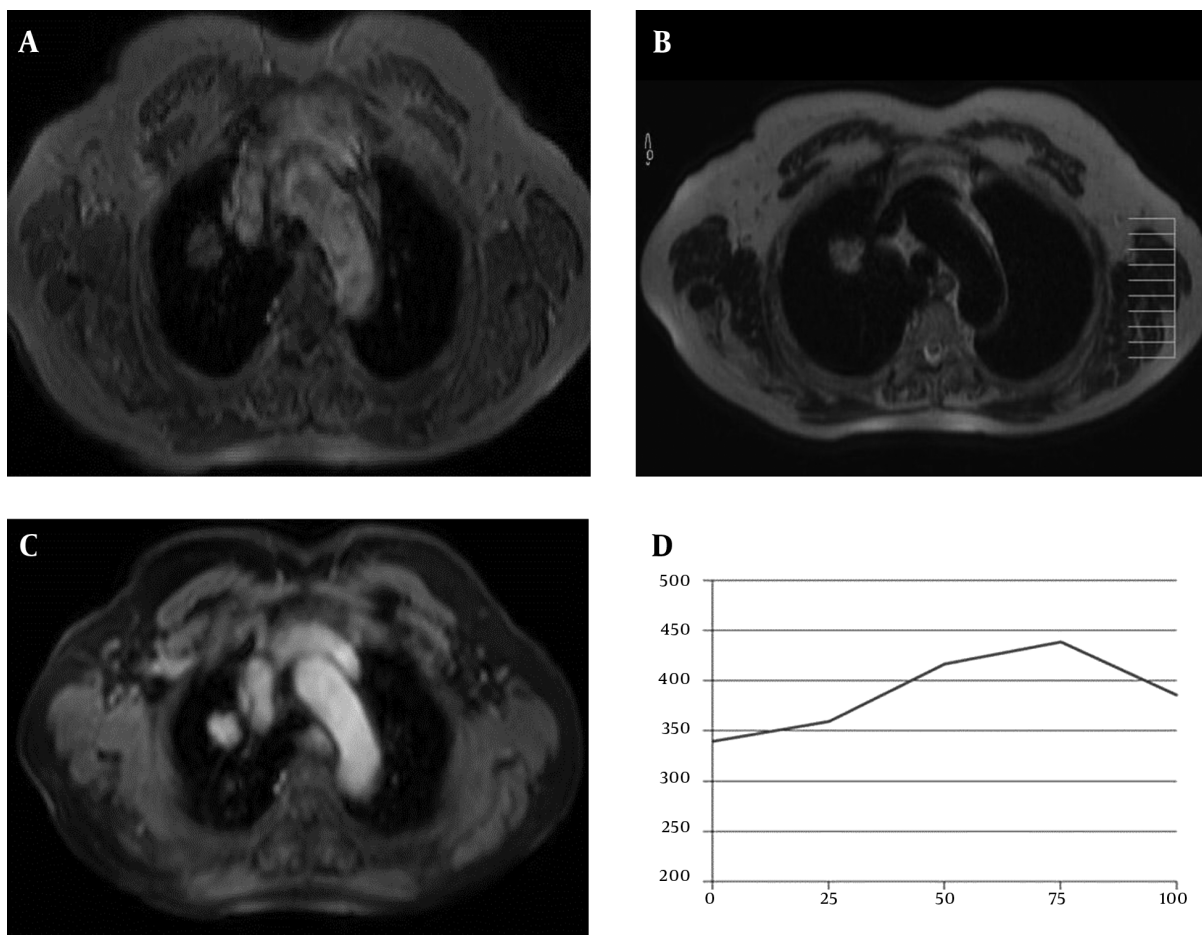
A 77-year-old woman with adenocarcinoma. A, Axial T1-weighted FFE and B, T2-weighted TSE, MR images show a mass in the right upper lobe of the lung; C, This mass shows prominent central homogeneous enhancement on the axial post contrast fat-suppressed T1-weighted image (5th minute); D, SI-time curve and quantitative interpretation of the curve obtained from the mass. Maximum relative enhancement (30%) and wash-in rate (2.28 seconds) implied benign mass.
